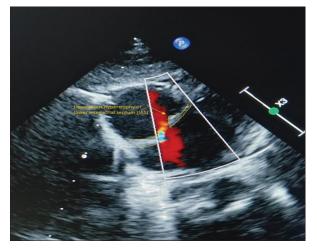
Lipomatous hypertrophy of IAS in subcostal modified apical 4 chamber view
